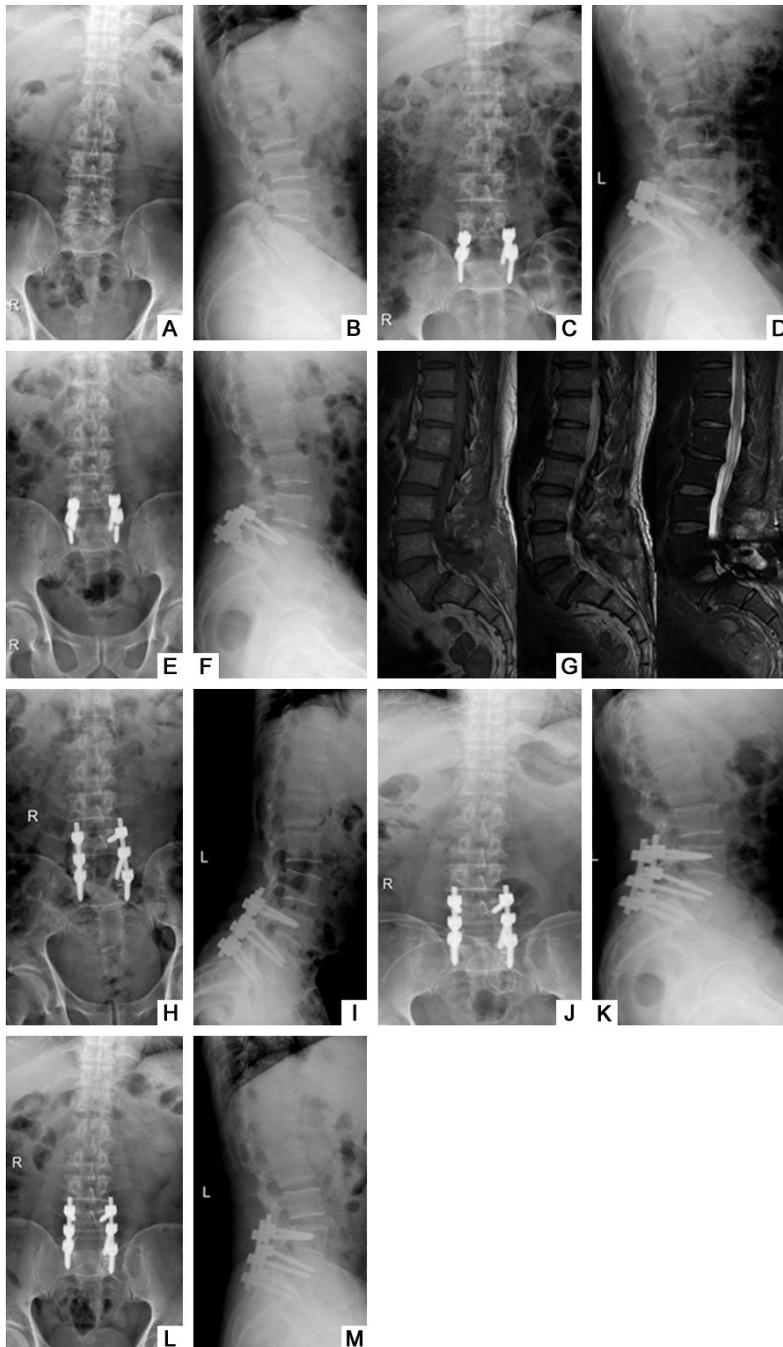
The radiography of the typical case. Male patients, 68, lower back pain for 7 months. Preoperative X-ray showed the L5 isthmic spondylolisthesis (degree V) (A, B); in February 2012, he underwent the surgery of posterior lumbar decompression and fixation and got the pain relief. (C, D). 4 months after surgery (June, 2012), he felt the back pain again. The X-ray showed the screw breakage (E, F); 5 months after surgery, the MR (G) showed a more severe slippage; he underwent the surgery to replace the severed screws with larger screws and to get the bone graft fusion. The symptoms alleviated after surgery, the postoperative X-ray (H, I) showed the reduction is successful. 6 months after the second surgery (January, 2013) (J, K) and 1 year after surgery (July, 2013) (L, M), The X-ray showed the fixation was stable and the patient got the total pain relief.
